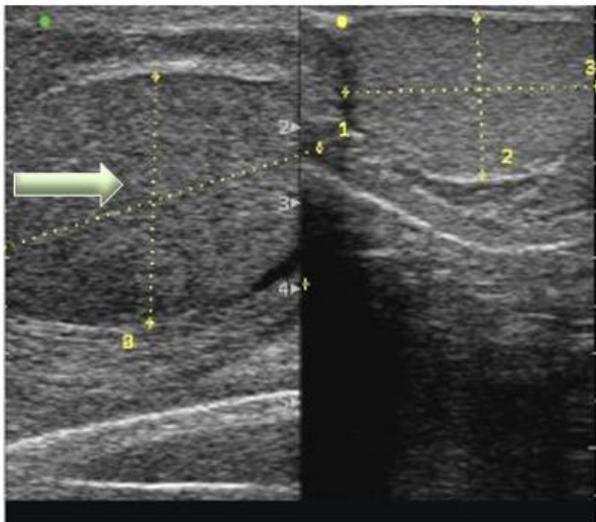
a: Diffusely enlarged testis with hypochoic echotexture (High frequency ultrasound image)
